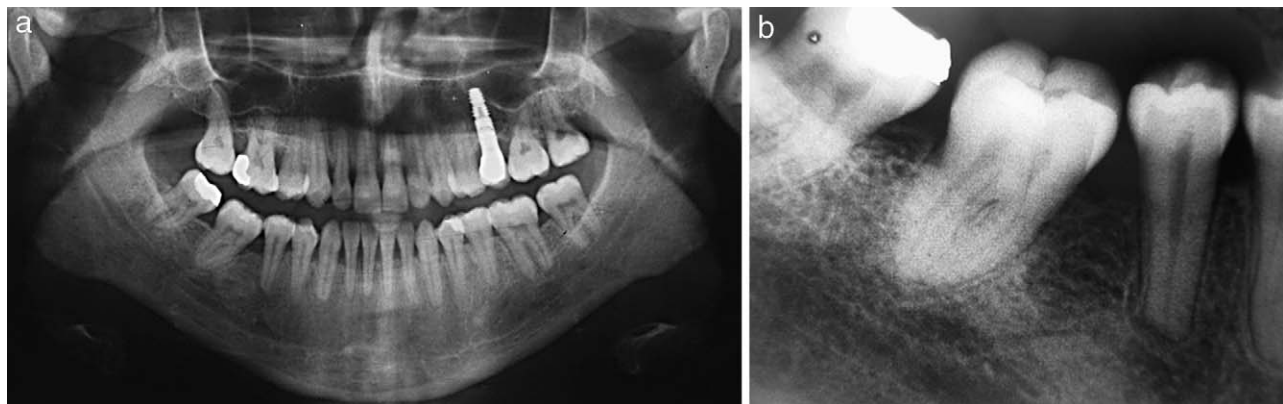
(a) Panoramic radiograph after 1 year posttreatment. (b) Periapical radiograph after 1 year posttreatment.
